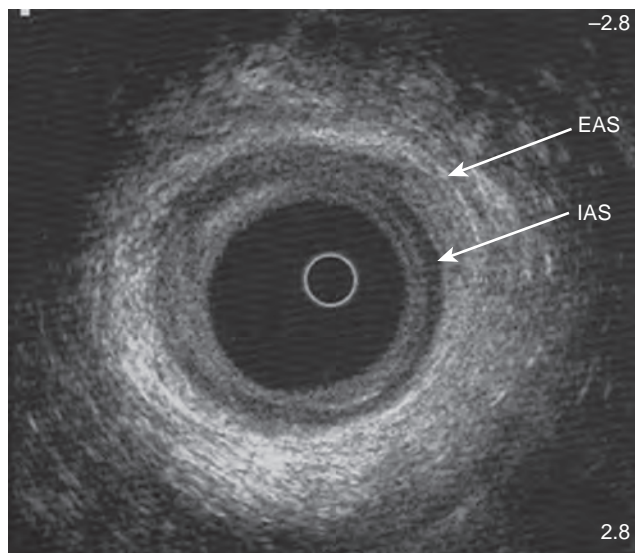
Endoanal ultrasound image in a normal female. EAS, external anal sphincter; IAS, internal anal sphincter.
